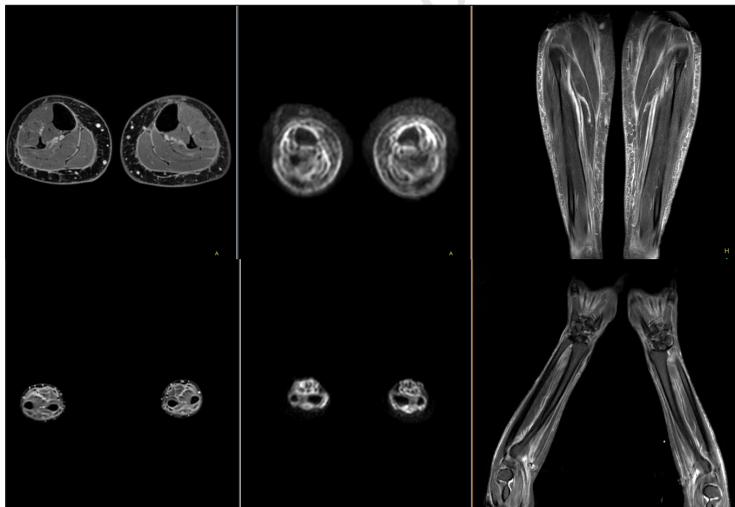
Forearms and legs MRI findings in patient with eosinophilic fasciitis showing prominent superficial and deep fascial thickening on axial T1-weighted images (A), diffusion contrast-enhanced weighted images (B), and coronal short STIR images (C).
